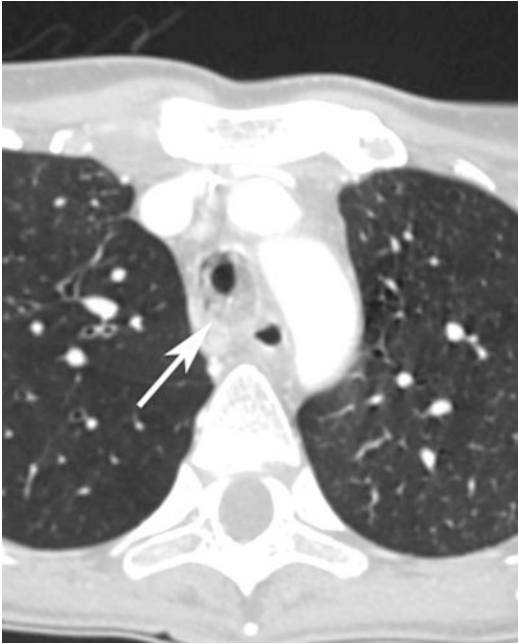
Post-contrast axial CT scan at the level of the upper mediastinum depicts a circumferential granulomas within the wall of the trachea (*white arrow*) with stenosis of the lumen
